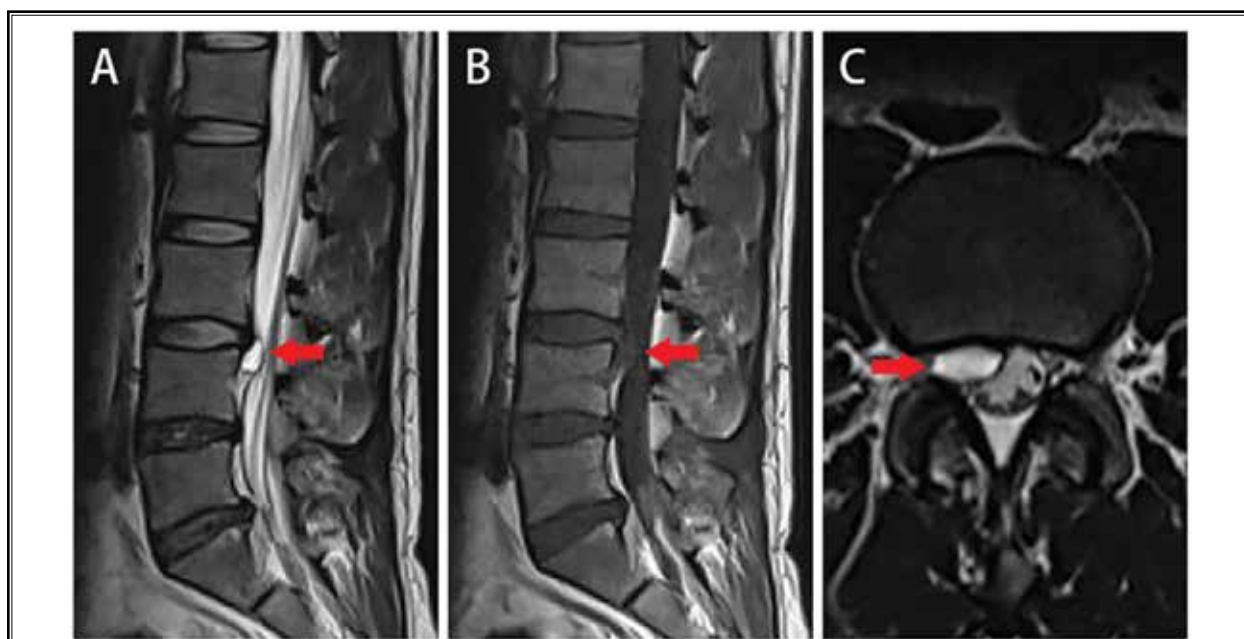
Preoperative MRI scans.
